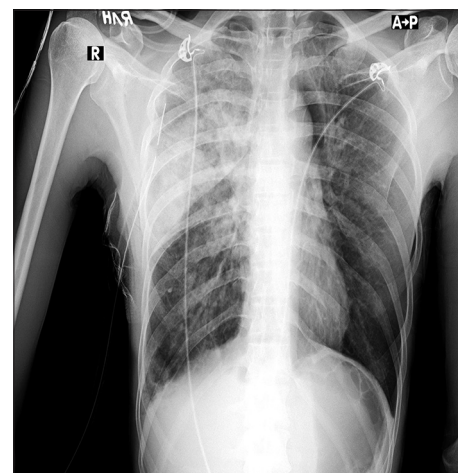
X-ray chest showing alveolar opacities in the right lung suggestive of pulmonary edema
